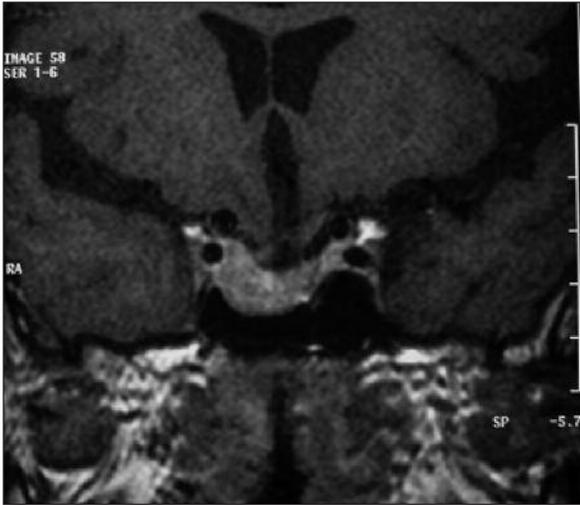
Pituitary MRI (coronal contrast-enhanced T1 weighted image). After high dose RAI ablation.
